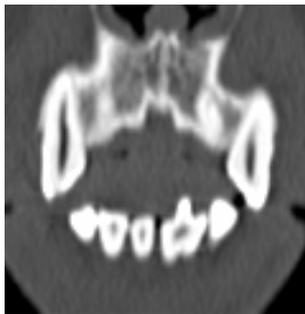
CT section showing the talon cusp on fused teeth 31 & 32
